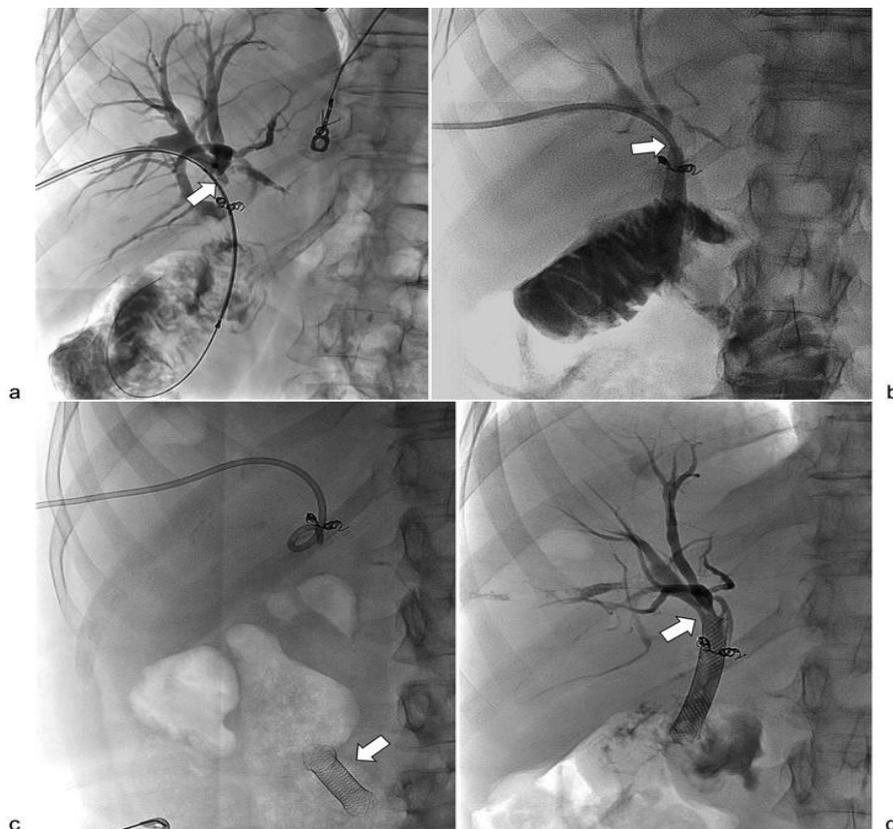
(a) A 49-year-old woman who underwent a Whipple procedure for pancreatic cancer presents with recurrent biliary obstruction. A short common bile duct is anastomosed to a Roux-en-Y. Hepatic arterial coils are related to prior iatrogenic haemobilia. Obstruction extends to the hilum, and a nondeployed 4-cm-long covered stent is preliminarily placed with the proximal end above the obstruction (arrow). (b) After deployment, the proximal end has migrated distally (arrow), and most of the stent protrudes into the Roux limb. (c) Abdominal radiograph obtained the next day shows stent migration distally into the small bowel (arrow). (d) A 4-cm-long
